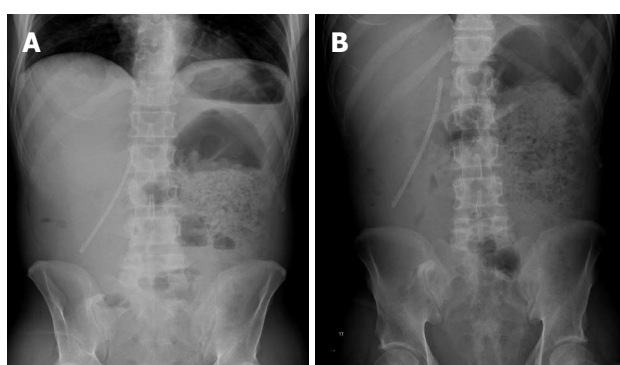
Abdominal X-rays showing an abnormal position of the biliary stent highly suspicious of distal migration with free air (A) and markedly dilated left side of colon and retained fecal material (B).
